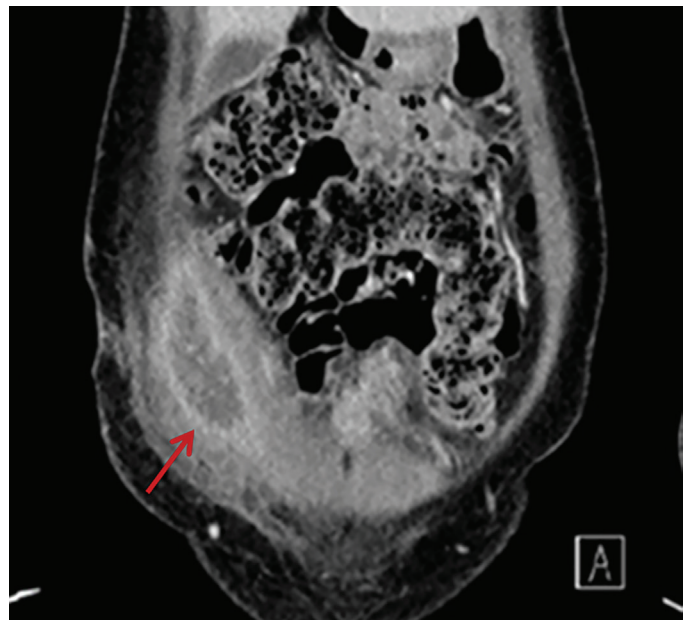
Coronal computed tomography abdomen and pelvis demonstrating a collection within the right abdominal wall musculature (right rectus and oblique muscles), measuring approximately 4.4 × 2.3 cm, with adjacent fat stranding.
